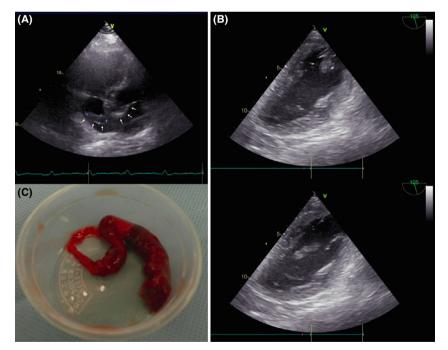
A, Transthoracic echocardiography of a 55-year-old man displaying a thrombus spanning the atrial septum. The thrombus moved to the left atrium side over time. B, Transesophageal echocardiogram during surgery also showed the thrombus trapped in the foramen ovale. The end of the thrombus was going back and forth between the left ventricle and atrium. C, The 20-cm thrombus removed by surgery.
